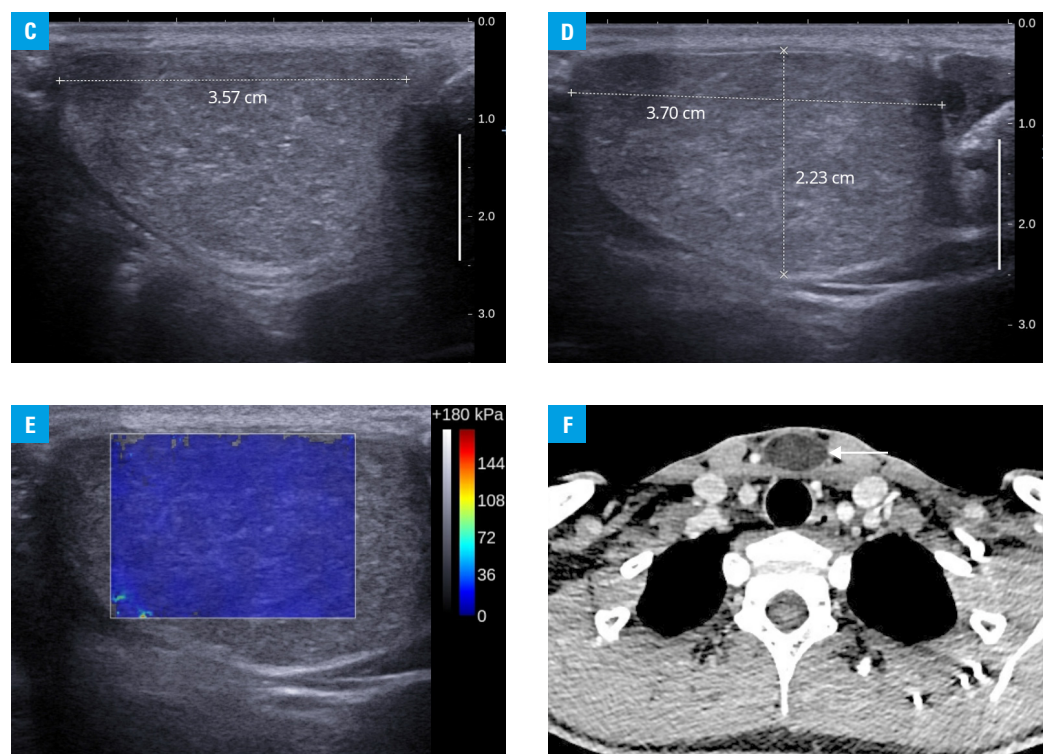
C, D – ultrasound image presenting a well-defined hypoechoic lesion in the longitudinal (C) and transverse sections (D); E – the result of sonoelastographic examination indicating high elasticity value; F – computed tomography image showing a 3.4×2.4 cm thin-walled cyst (arrow) without pathological contrast enhancement at the level of suprasternal notch and no abnormalities within the neighboring structures
